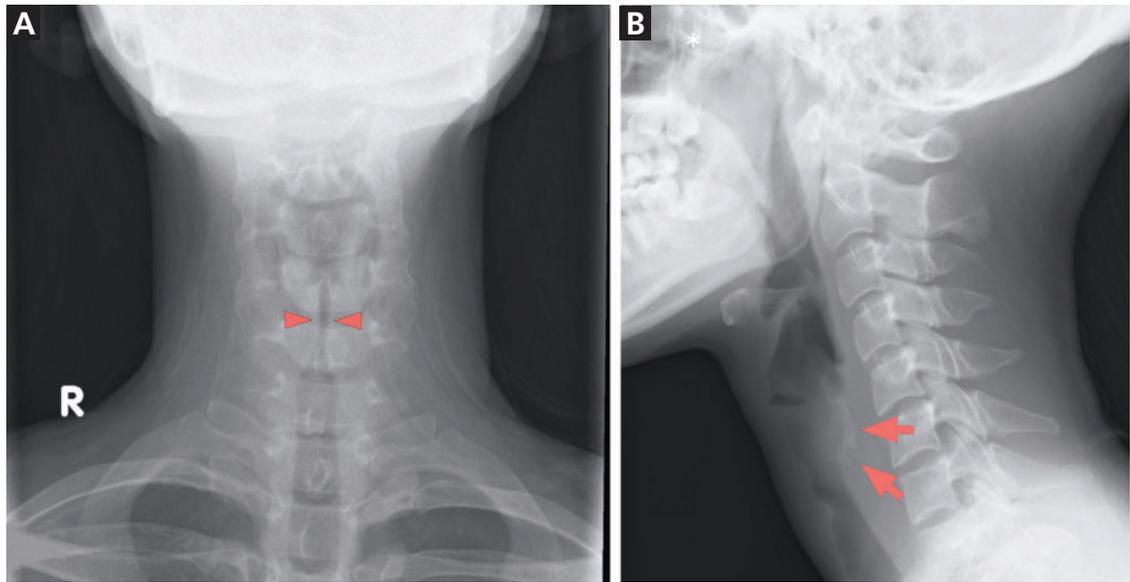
Radiography showed (A) narrowing of the upper trachea (arrowheads) and (B) calcification of tracheal cartilage (arrows).
